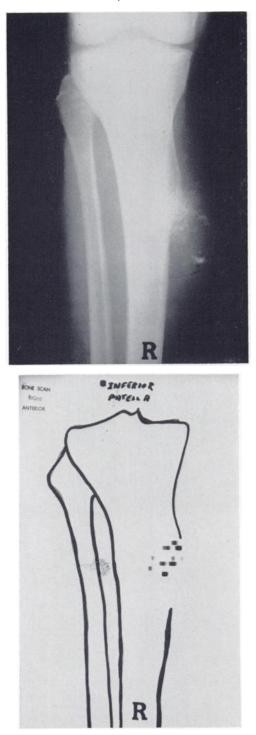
Case VI. Chondrosarcoma. (a) Anteroposterior roentgenogram revealed a calcified soft tissue mass arising from the right tibia. (b) Anterior scan revealed increased ⁸⁵Sr only at the tumor's origin from the tibia; this is consistent with the cartilaginous nature of the neoplasm.
